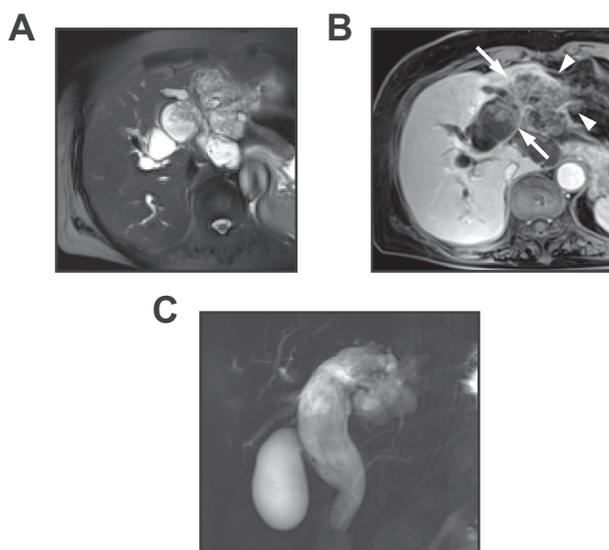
Images in a 65-year old-woman with surgically confirmed intraductal papillary neoplasm of the bile duct with an associated carcinoma. (A) T2-weighted image shows dilatation of the bile duct with multiple intraductal papillary masses. The largest tumor size is 3.6 cm. (B) Portal phase contrast-enhanced MR image shows bile duct wall thickening (arrows) and adjacent organ invasion (arrowheads). (C) MR cholangiography image shows diffuse dilatation of intra- and extrahepatic bile ducts with papillary intraductal masses. MR, magnetic resonance.
